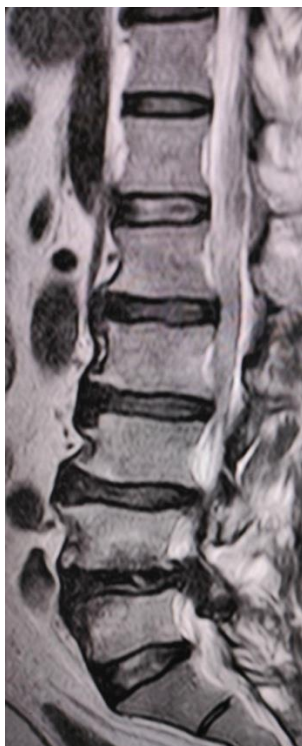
T2 weighted MR image shows disc herniation at L4-L5 Level of lumbar spine
